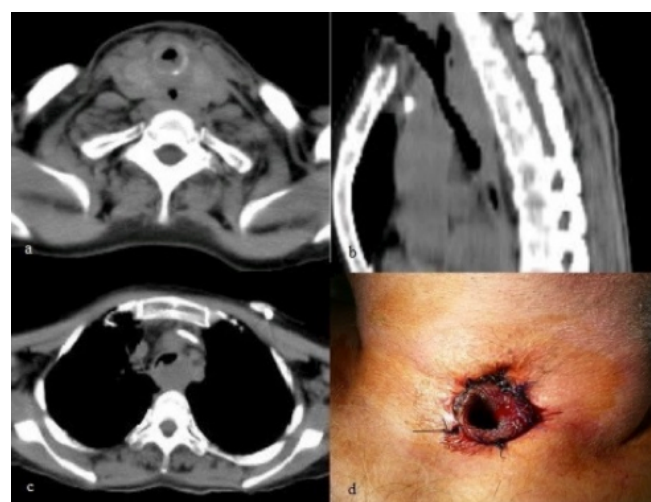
Thorax CT images of case 2, d. stoma image of same case.
